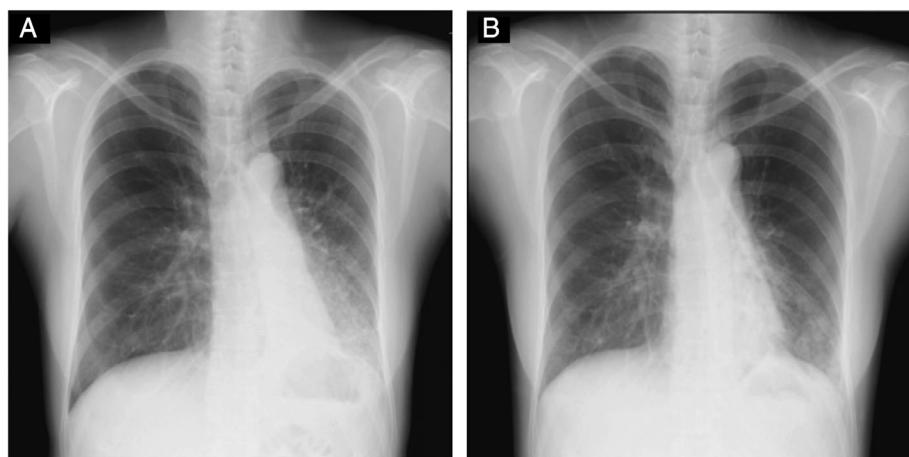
Chest X-ray on second admission. (A) The chest X-ray on admission shows consolidation and atelectasis in the left lower lung. (B) The chest X-ray after treatment shows remission of the consolidation in the left lower lung.
